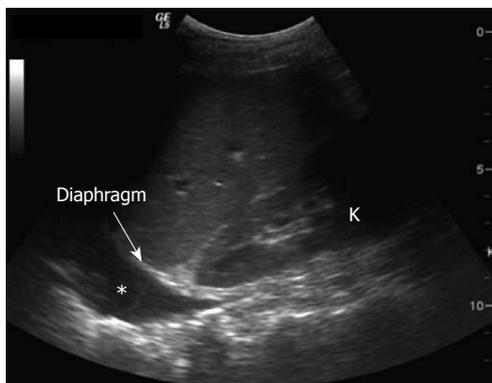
Hemothorax on bedside ultrasonography. Hemothorax can be seen as hypoechoic area (asterisk) above the liver. Of note, movement of the lung within the pleural fluid can often be appreciated during the progression of the respiratory cycle. The kidney (K) and the diaphragm (arrow) can be easily seen, with the wedge of the liver located above.
